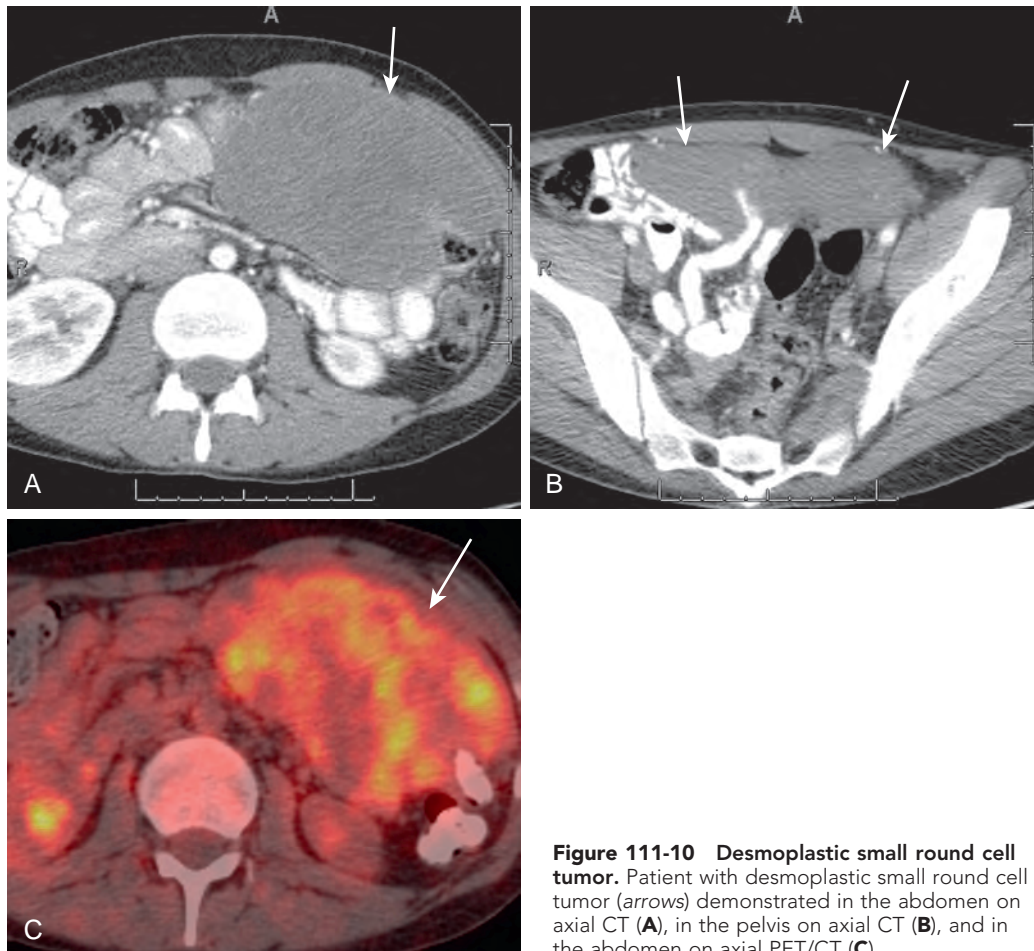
Desmoplastic small round cell tumor. Patient with desmoplastic small round cell tumor (arrows) demonstrated in the abdomen on axial CT (A), in the pelvis on axial CT (B), and in the abdomen on axial PET/CT (C).
